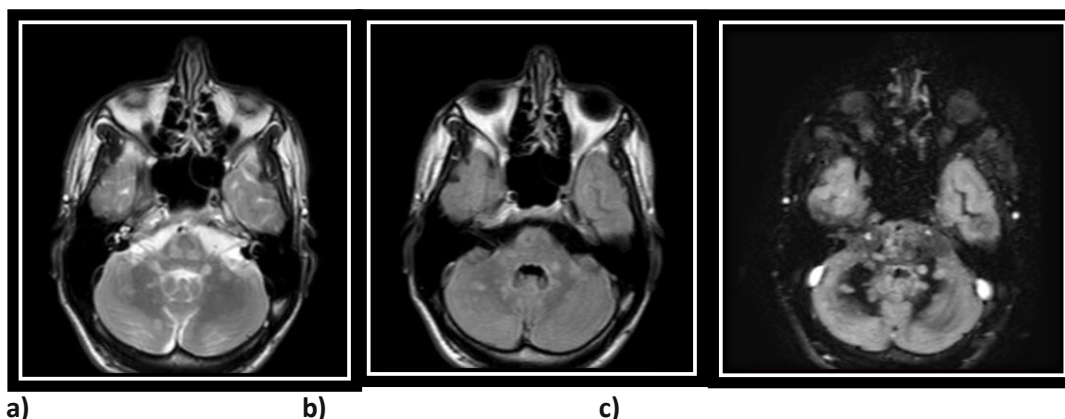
Axial MRI brain images at the same level in a 29 years old female patient with MS a) T2-TSE, b) FLAIR & c) DIR, show better delineation of peri-ventricular and juxta cortical lesions. Note lesions in occipital region considered juxta cortical in both T2 & FLAIR sequences, in DIR appear to be mixed W/GM lesions.
